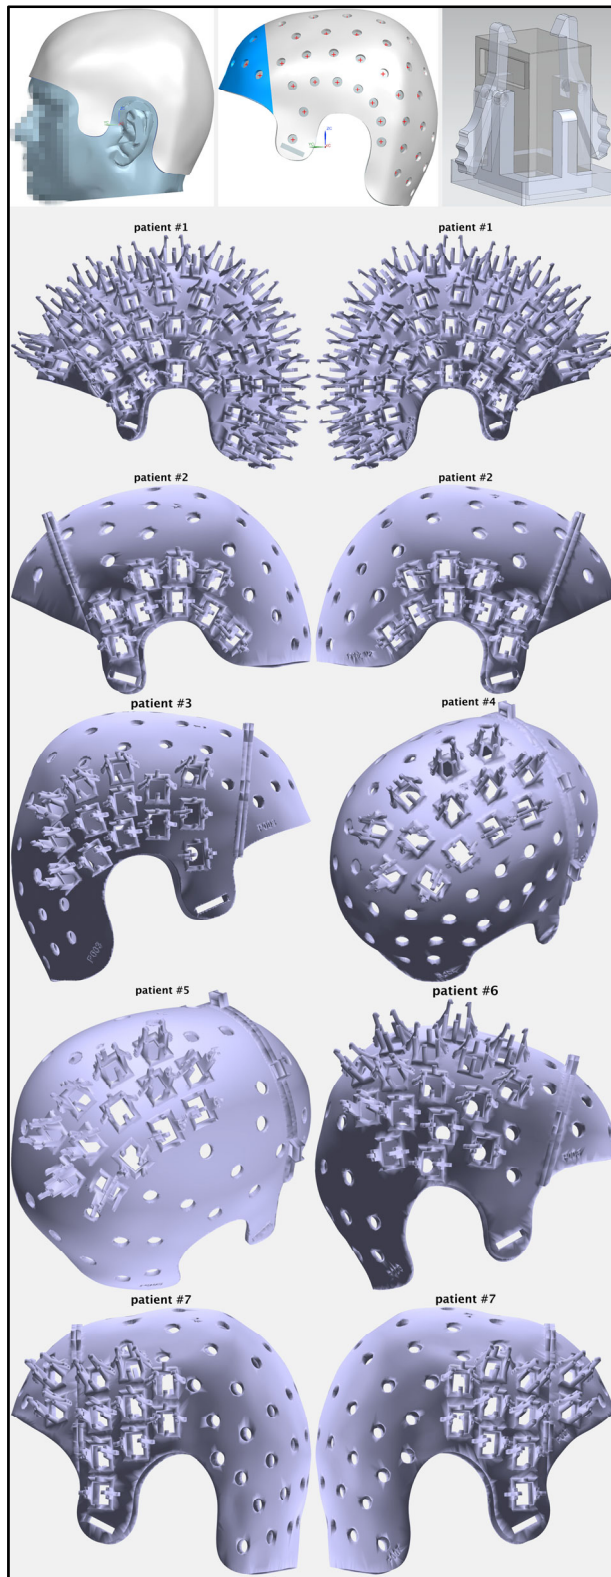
Helmet design, and helmet-models for all 7 patients. A 3D model of the scalp surface was created from the patient’s anatomical MRI, from which the basic helmet-shape was extracted (top-left panel). A standard layout was projected onto this helmet (red markers; top-middle panel), and holes for heat-dissipation were created at these positions. A removable cap was created and holes for a chin-strap were added, as well as individual sensor-holders (top-right panel). The field maps of IEDs that had been identified in the previously recorded clinical MEG were used to guide the sensor placement (see Figure 3). That is, the sensors were placed so that the (expected) dipolar pattern would be captured with the sensors, including the two field extrema. Stereo-EEG recordings were used as gold-standard for confirmation of the location of the IEDs as identified in the previously recorded clinical MEG.
